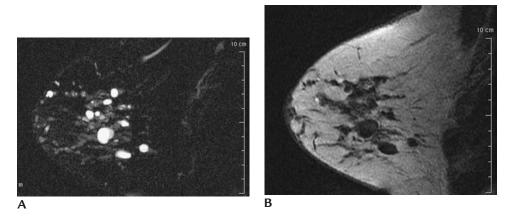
Cysts, magnetic resonance imaging. (A) Sagittal T2-weighted fat suppressed image. Multiple masses of varying sizes characterized by bright signal. (B) Sagittal T1-weighted image, same table top position as in (A). Low signal intensity for the same masses seen on T2-weighted images. When associated with inflammatory changes, these may demonstrate rim enhancement.
